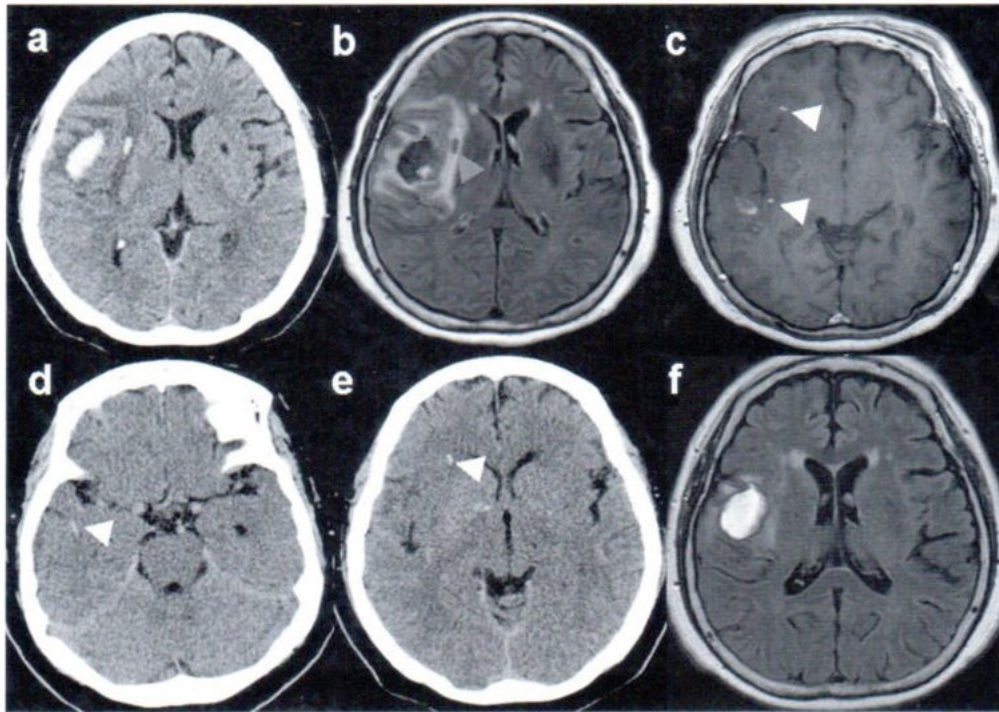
Noncontrast brain CT (a). MRI FLAIR sequence (b) showed expansion of the perihematoma brain swelling and a new small acute hemorrhage at the right external capsule (red arrows). MRI T1WI (c) showed two hyperintense thrombosed intrasylvian veins which was neglect on the initial brain CT (yellow arrows) (d, e). One month follow up MRI FLAIR sequence (f) after treatment with LMWH showed marked regression of the T2 hyperintense brain swelling and stable in size of the previous hematoma.
